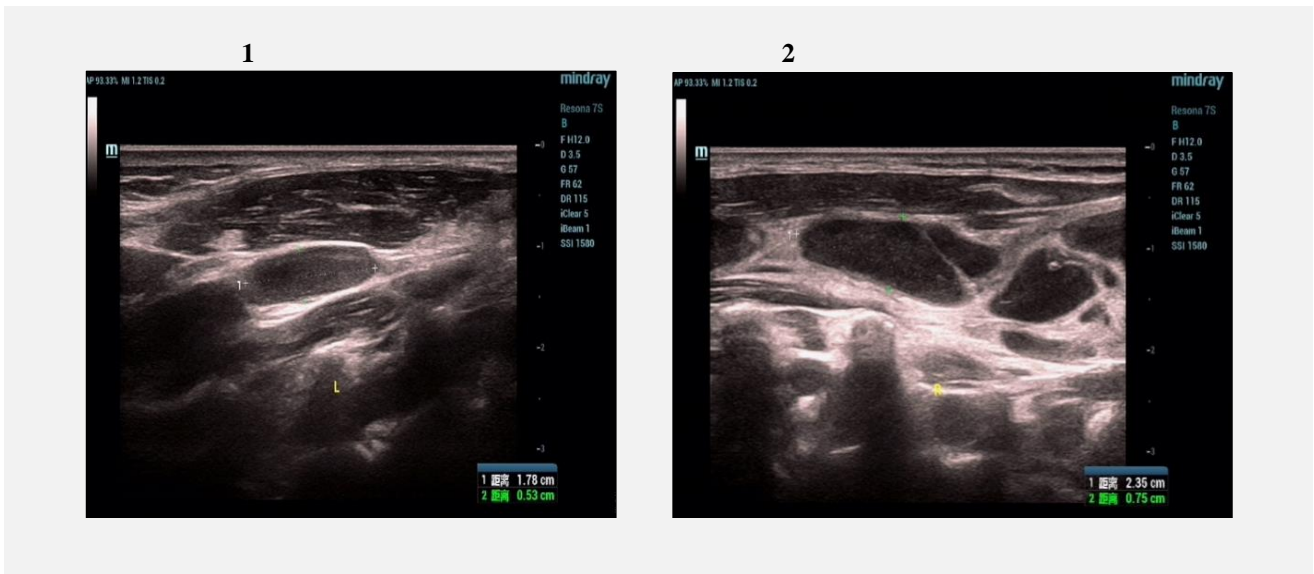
2. Cervical Lymph Node Ultrasound: Multiple hypoechoic areas with thickened cortex are observed in regions I - IV on the left side of the neck, the largest located in region I, measuring approximately 23.8 x 7.0 mm. CDFI: Hilar blood flow signals are visible within all of them. Multiple hypoechoic areas with thickened cortex are observed in regions I - V on the right side of the neck, the largest located in region I, measuring approximately 39.8 x 9.6 mm.
